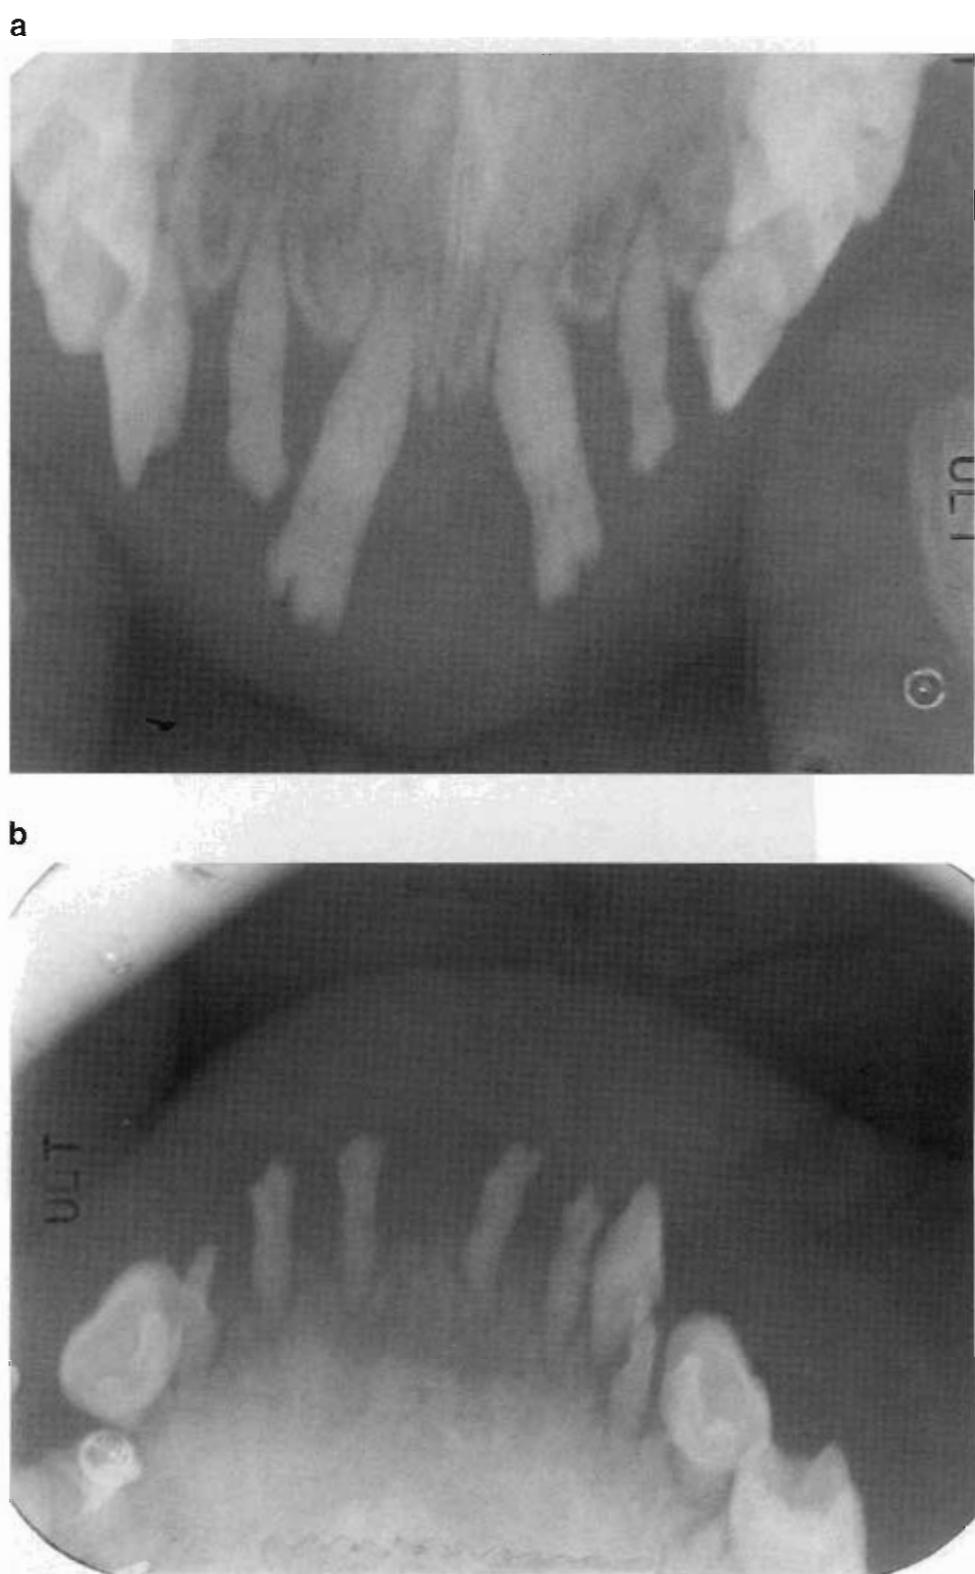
Periapical radiographs of Maxillary and mandibular incisors of Patient 1 (a) and (b). Patient 2 (c) and (d). Note Severely hypoplastic alveolar bone. Obliteration of dental pulp chambers and root canals.
